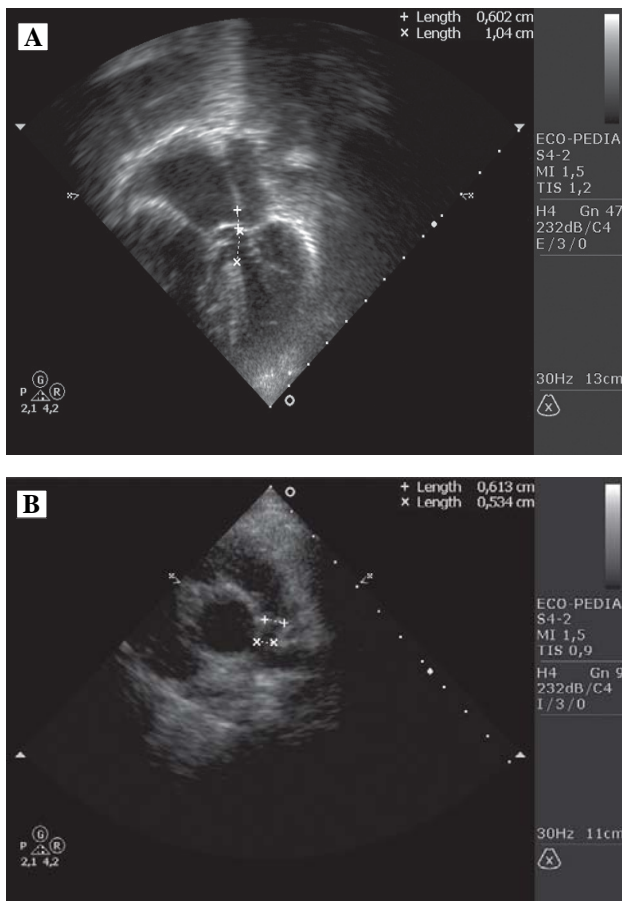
A: Echocardiogram in apical cut, four chambers in systolic cycle evidencing dilation of the right chambers with hypertrophy of the right ventricle and the diameters of the atrial septal defect ostium primum: (+) of 6 mm and the entricular septal defect (X) of 10 mm. B: Echocardiogram in parasternal cut, short axis at the level of the base vessels showing mild dilation of the ascending Ao and stenosis of the pulmonary trunk with its diameters in the medium segment (+) and distal (X) of 6.1 and 5.3 mm respectively. AE: left atrium, AD: right atrium, VE: left ventricle, VD: right ventricle, Ao: aorta, TP: pulmonary trunk, CIA: atrial septal defect, CIV: ventricular septal defect
